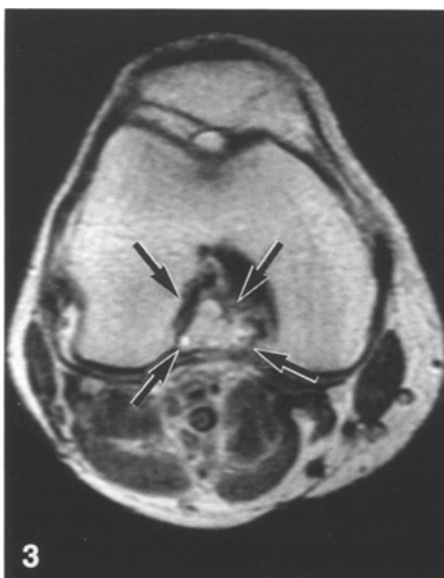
A transaxial T₂-weighted MR image shows a mass of 15 mm (arrows) arising from the proximal third of the posterior cruciate ligament
